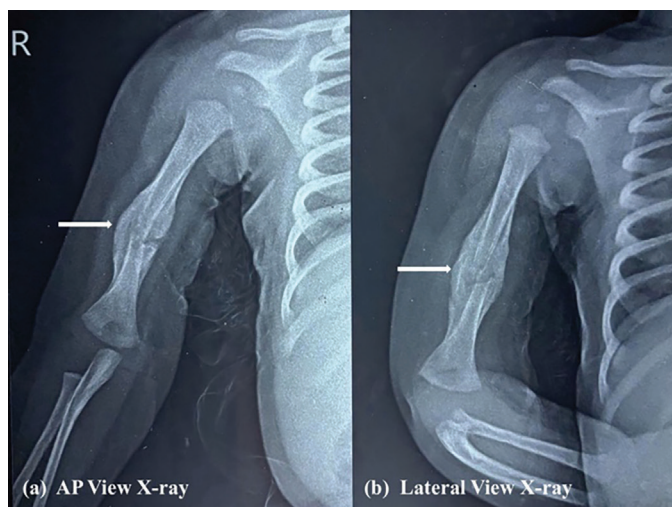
AP (a) and lateral (b) X-ray views of the right humerus at six weeks show abundant callus at the fracture ends, suggesting complete fracture union (arrow)
